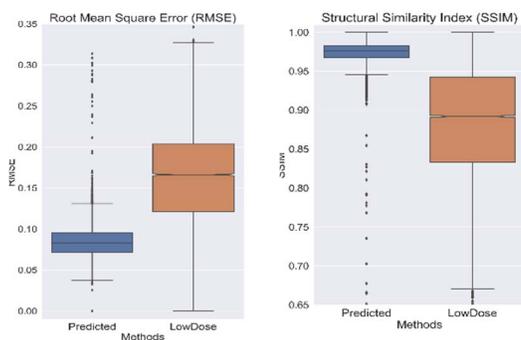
SSIM and RMSE metrics calculated of the low-dose and predicted high-dose CT images.
